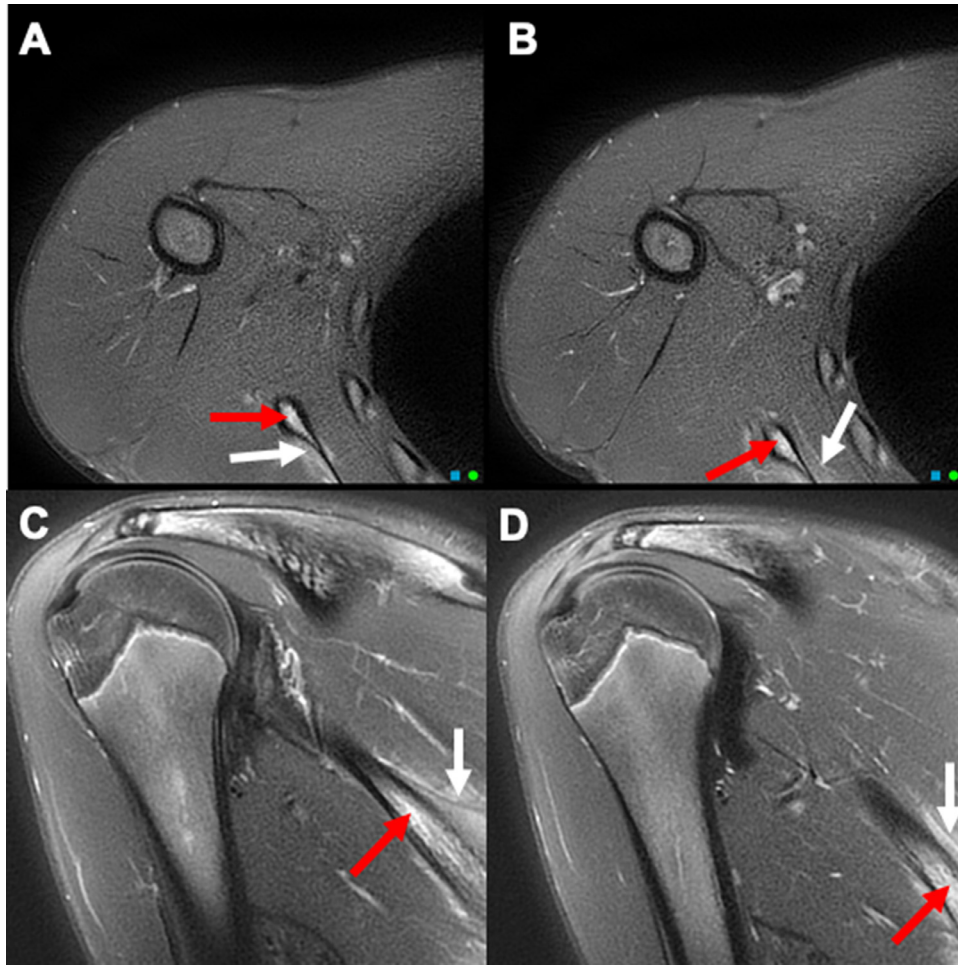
Right shoulder routine MRI axial PD (proton density) sequence (A and B) and coronal T2 fat suppressed sequence (C and D) shows partially visualized hyperintensity/edema involving the lower body of the scapula (red arrows) and adjacent soft tissue (white arrows).
